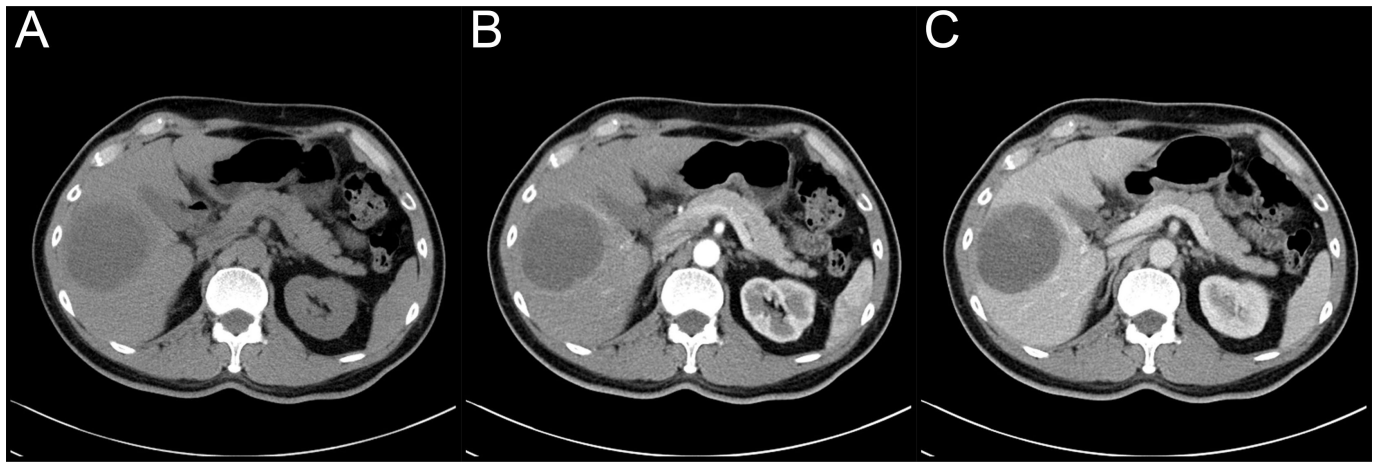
Preoperative CT evaluation (A) plain CT scanning (B) artery phase of enhanced CT scanning (C) portal vein phase of enhanced CT scanning.
